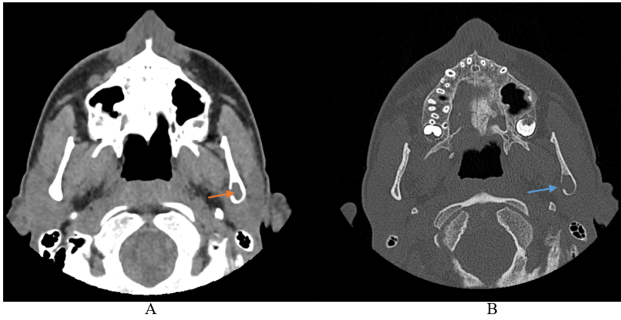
Axial unenhanced CT demonstrates an expansile lytic lesion within the left mandibular ramus. A): Soft tissue attenuation is demonstrated centrally on soft tissue window (orange arrow); B): Cortical breakthrough along the lesion’s medial border is demonstrated on bone window (blue arrow)
